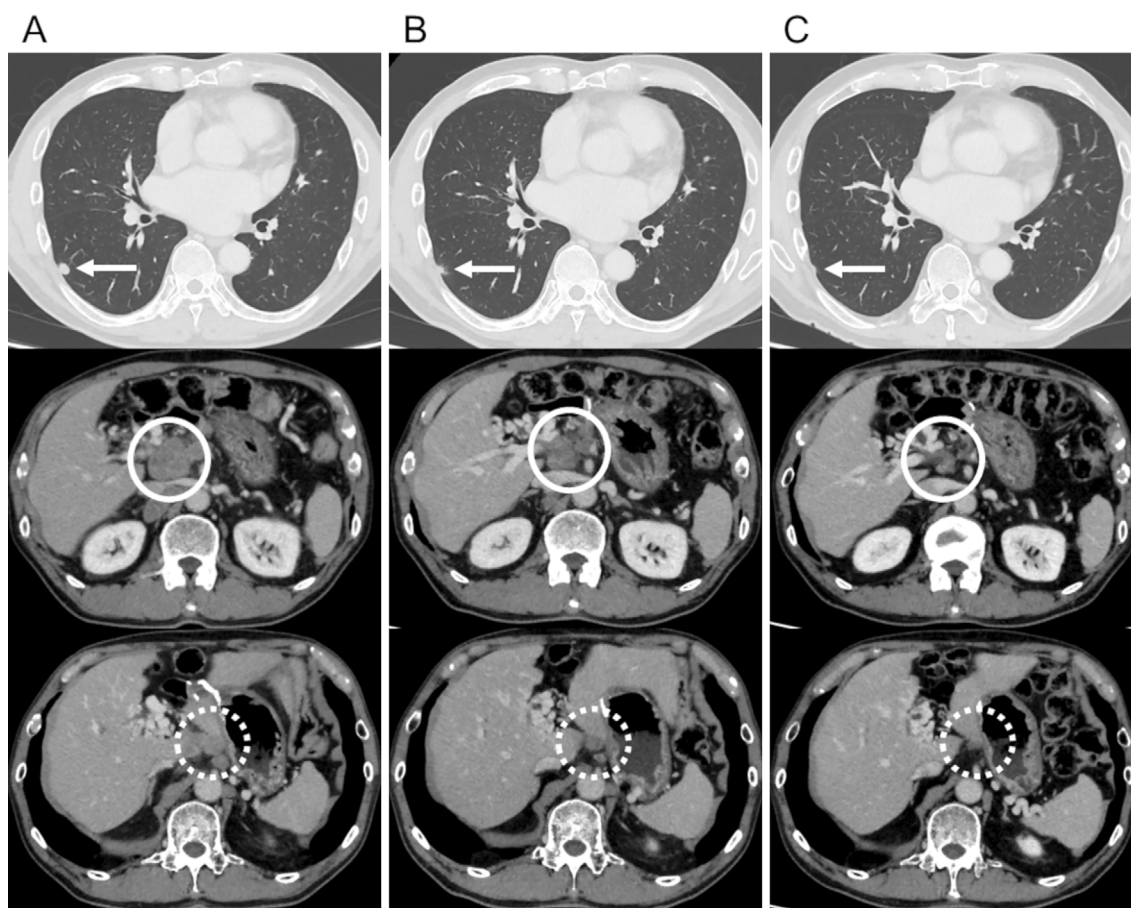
(A) Abdominal computed tomography images before the commencement of nivolumab treatment. Solitary lung metastasis (arrow), portal tumor thrombus (solid circle), and multiple lymph node metastases (dotted circle) were observed. (B) After four cycles of nivolumab (approximately 2 months after start of nivolumab), the metastatic lesions shrank to 61.2% of the original size (before nivolumab treatment). (C) Twenty-three months after the discontinuation of nivolumab, the metastatic lesions further shrank to 39.1% of the original size (before nivolumab treatment).
